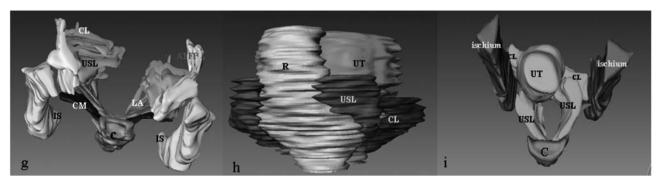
Healthy female MRI 3D models. Panel g, from above behind observe the anatomical relation between the CL, USL, IS, ATFP and LA. Panel h, from behind observe the anatomical relation between the CL, USL, rectum and uterus. Panel i, from above observe the anatomical relation between the CL, USL, uterus, coccyx and ischium. B=bladder, UT=uterus, R=rectum, IS= ischium, C=coccyx, CM=coccygeus muscle, LA=levator ani, ATFP=arcus tendineus fasciae pelvis, CL=cardinal ligament, USL=uterosacral ligament.
